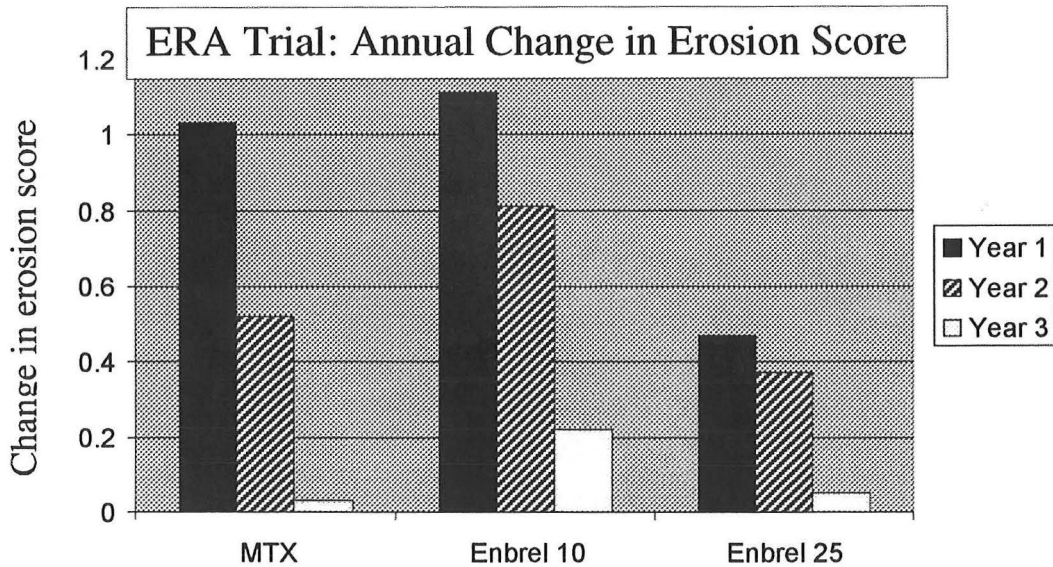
Radiographic progression in the ERA trial. Etanercept given 25 mg sc 2x/week (Enbrel 25) resulted in significantly less deterioration in the erosion score than did methotrexate plus placebo (MTX) or etanercept 10 mg sc 2x/week (Enbrel 10).
